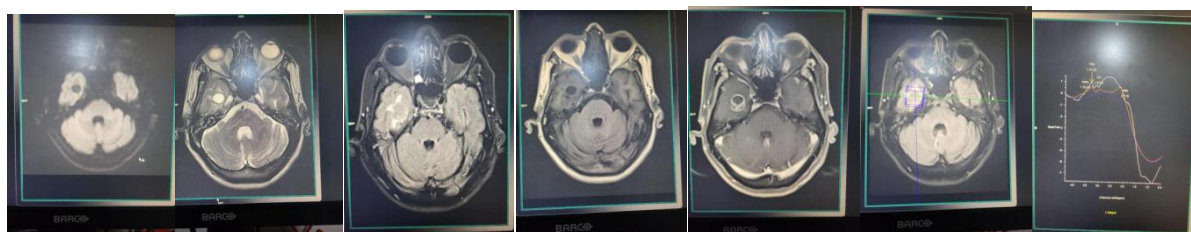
Shows No restriction on DWI with adjacent perilesional edema noted in right temporal lobe region with Cholin peak on MRS S/O Metastasis, in T1 hypointense, T2 FLAIR hyperintense lesion with hypointense rim
